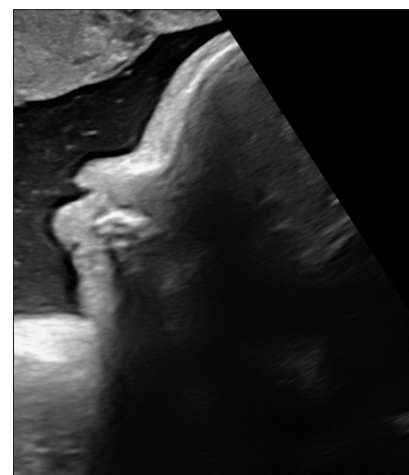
Third-trimester ultrasound: midsagittal section showing abnormal receding position of the chin in relation to the upper lip
